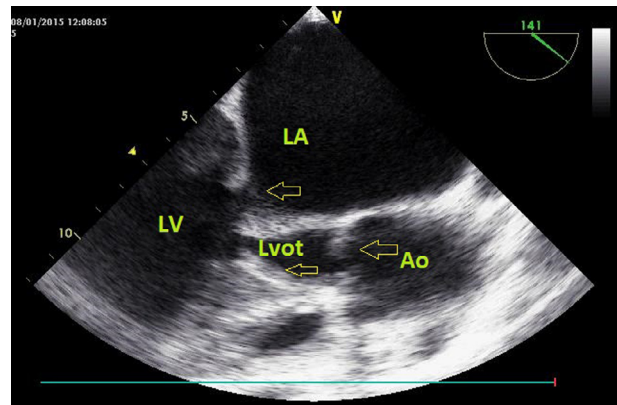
Transesophageal echocardiogram showing vegetation on the ventricular side extending to the mitral and aortic leaflet. Ao = aorta; LA = left atrium; LV = left ventricle; Lvot = left ventricular outflow tract.
